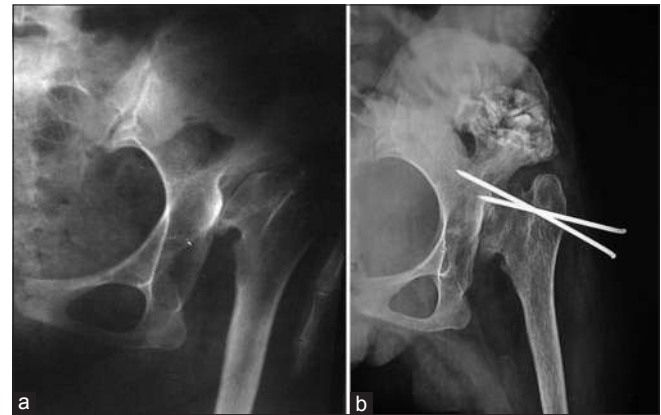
X-ray left hip anteroposterior view showing (a) old healed tubercular arthritis hip with dislocation. (b) Tactoplasty after pulling the head down. For initial six weeks, temporary stabilization is provided by k wire fixation, to be removed around 6 weeks
